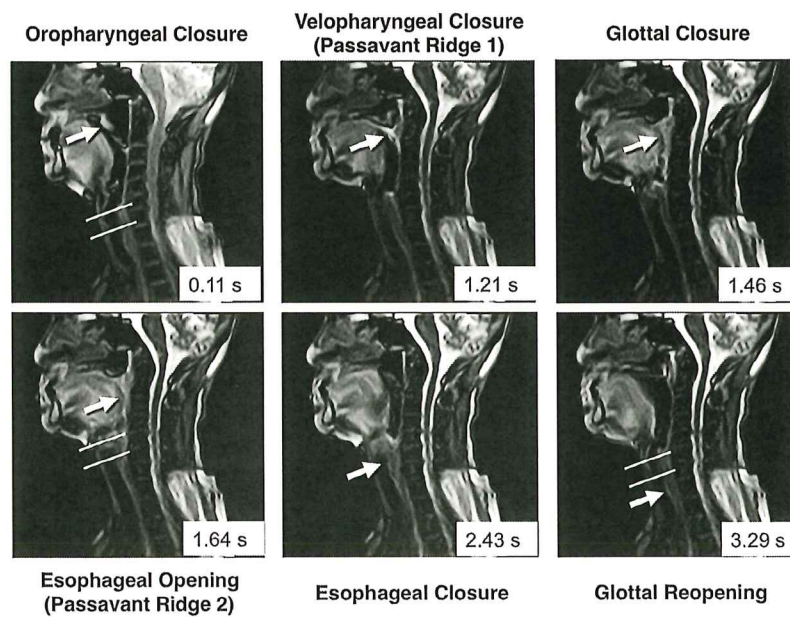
A good-quality swallowing series in the midsagittal plane obtained by using high-speed continuous magnetic resonance imaging (HSCMRI) before subtotal glossectomy (STGS) with tissue flap reconstruction in a 70-year-old man with cancer of the left tongue. The swallowing is successful after 2 attempts.
